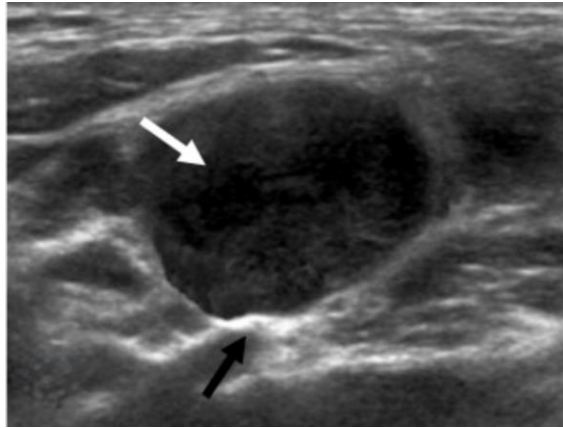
Ultrasound Appearance of a Tuberculous Lymph Node: Necrotic Node with a Hypoechoic Center and a Hyperechoic Capsule
